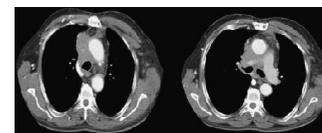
Chest CT shows a solid mass in the right hilar region.
